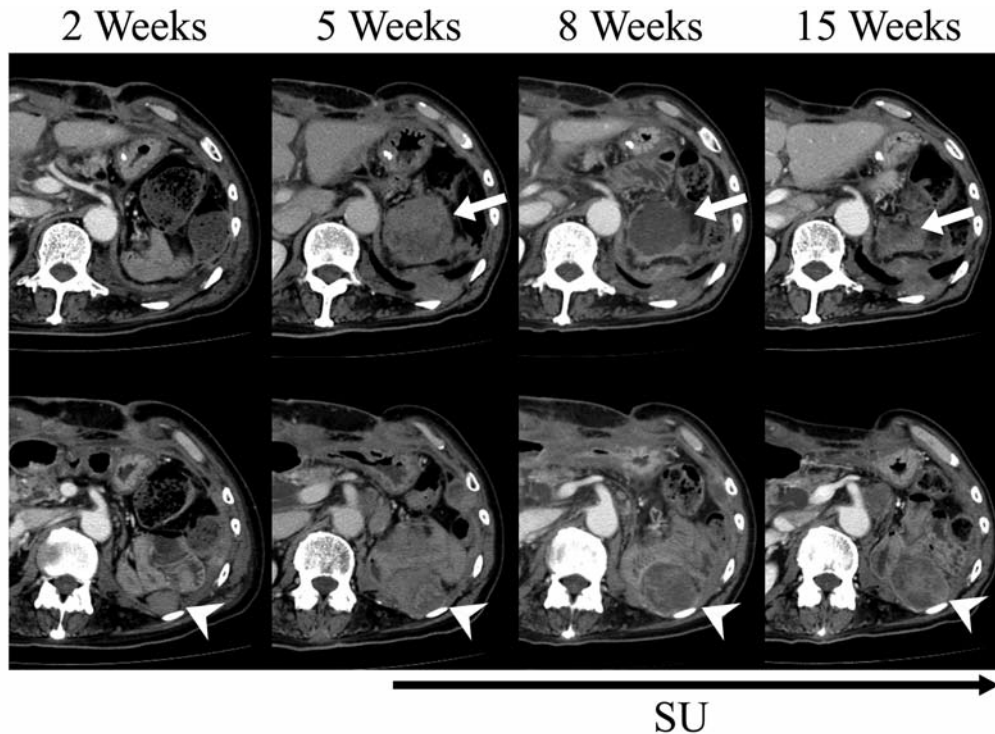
Post-operative computed-tomographic (CT) scans of the abdomen before (left two panels) and after (right two panels) sunitinib (SU) treatment. CT images show recurrent tumors in the retroperitoneal space, one of which was sensitive (upper panel, arrows) and the other of which was resistant (lower panel, arrowheads) to sunitinib.
